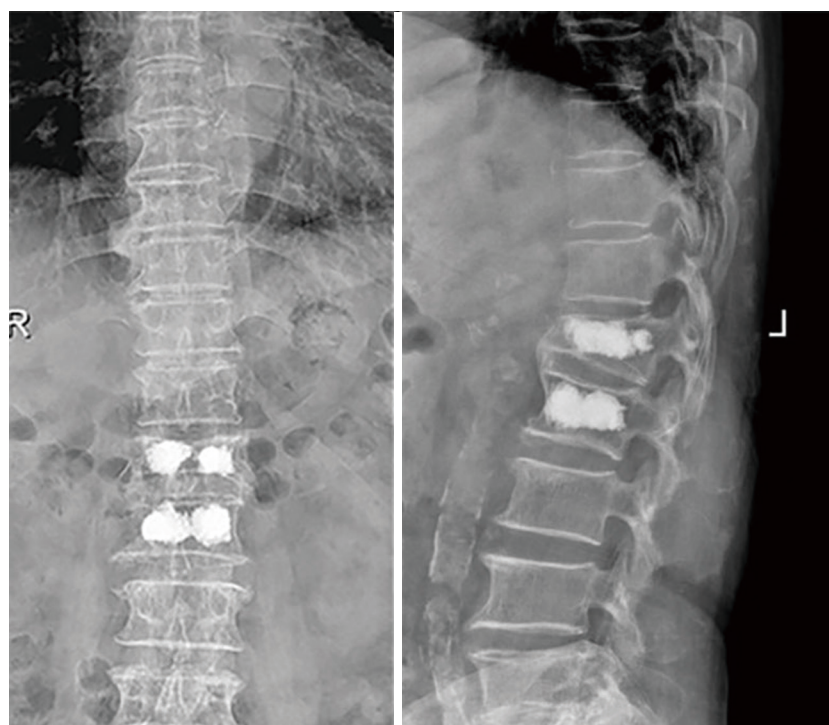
Postoperative lateral X-ray images showing the cement within the fractured L1 and L2 vertebrae distributed well and no cement leakage after percutaneous kyphoplasty (PKP).
